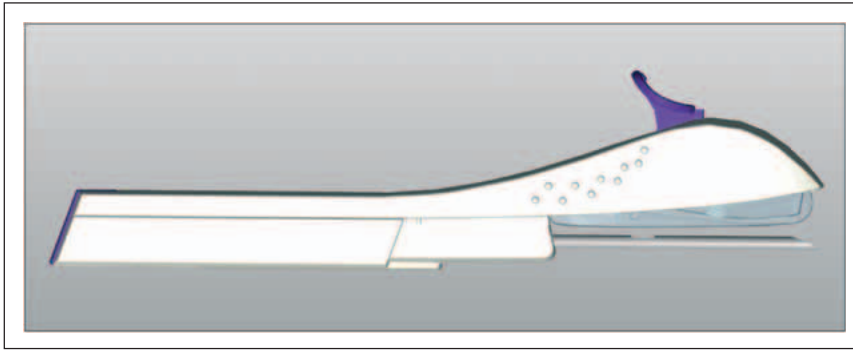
Implanon NXT (due to the content of barium sulfate it can be easily located by x-ray). Reprint with permission from MSD.
